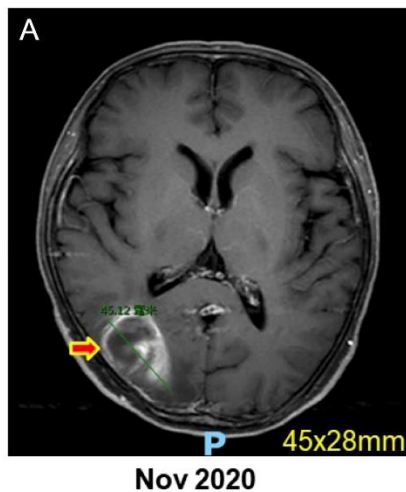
(A) Brain MRI showed right parietal-occipital hemorrhage suspicious from metastasis (Nov 2020). (B) The lesion remarkably subsided with very faint enhancement (March 2021).
